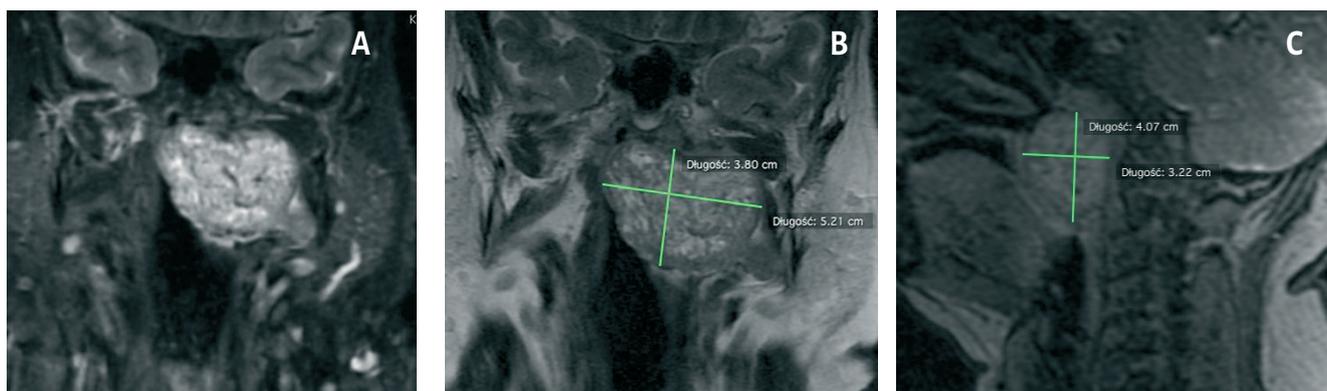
Magnetic resonance imaging of left-sided parapharyngeal and nasopharyngeal hemangiopericytoma (2a, 2b, 2c).
